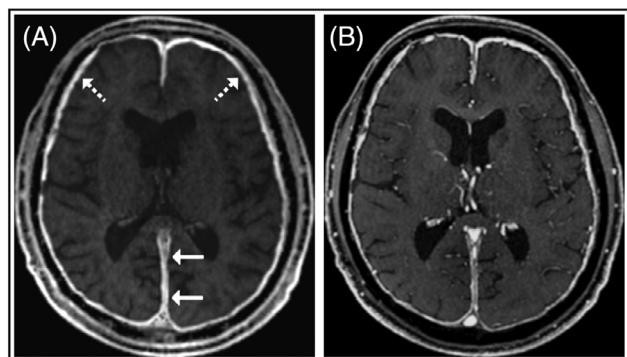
Synthetic (A) and conventional (B) post-contrast T1-weighted images in a patient with chronic intracranial hypotension. The intense, ribbon-like contrast enhancement of thickened pachymeninges, a typical finding of this condition, is appreciable in synthetic imaging in both the pachymeninges up against the inner table of the skull (dashed arrows in A) and at the level of dural reflections of the falx cerebri (arrows in A).
